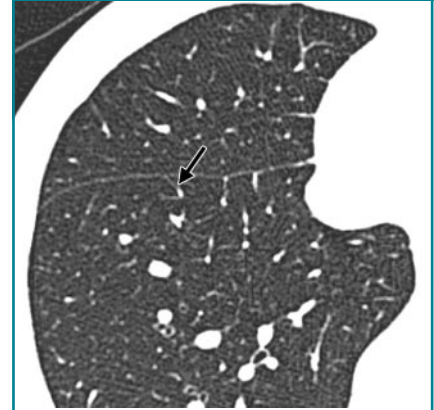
Transverse CT scan shows interlobular septum (arrow) in a healthy individual.
